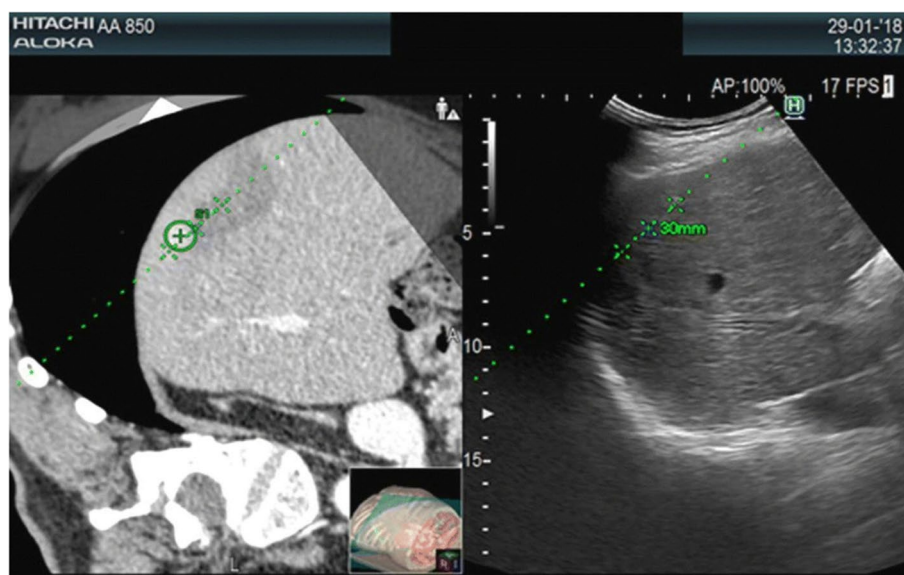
CT-US image fusion of small hyper-vascular nodular recurrent HCC close to a previously ablated area [14]
